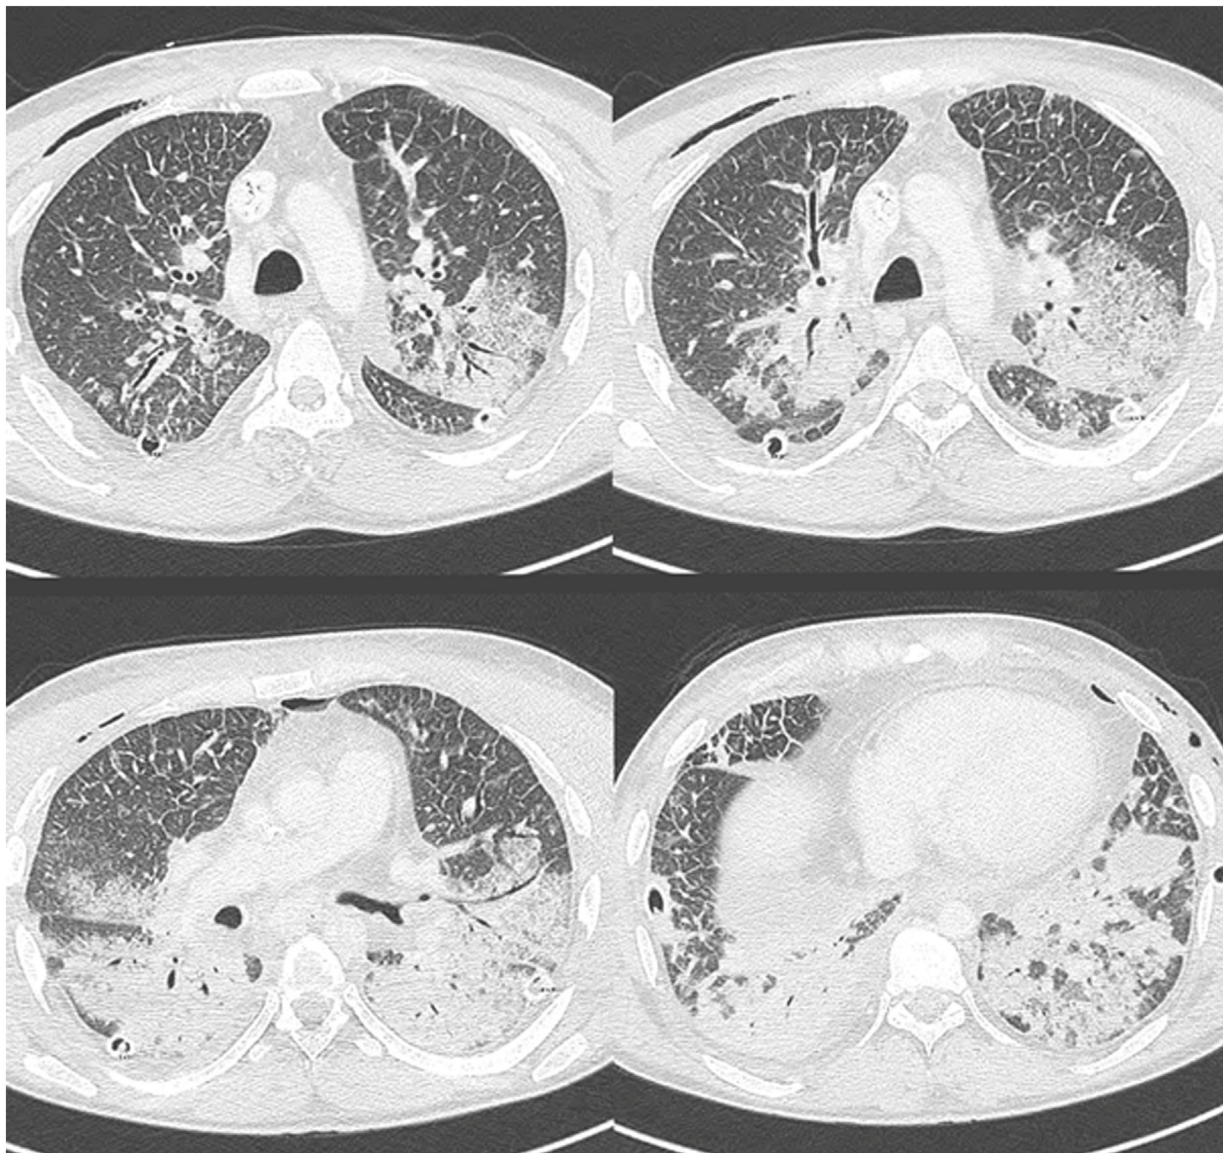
Chest CT scan on POD10.
